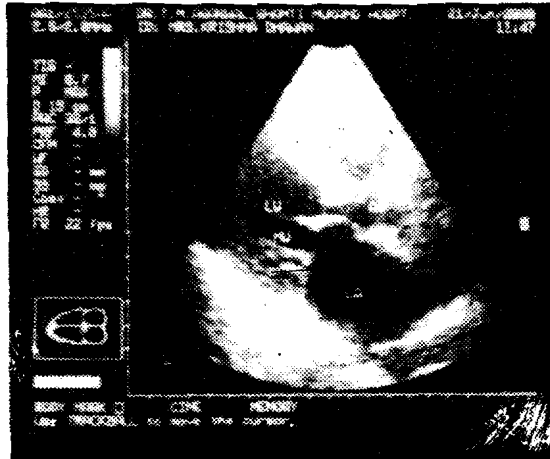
Echocardiogram of a 70 year old female patient with RIIID with MS showing Mitral valve stenosis with left atrium enlargement (courtesy Dr. S. Dwivedi and Dr. S.S. Giri)
